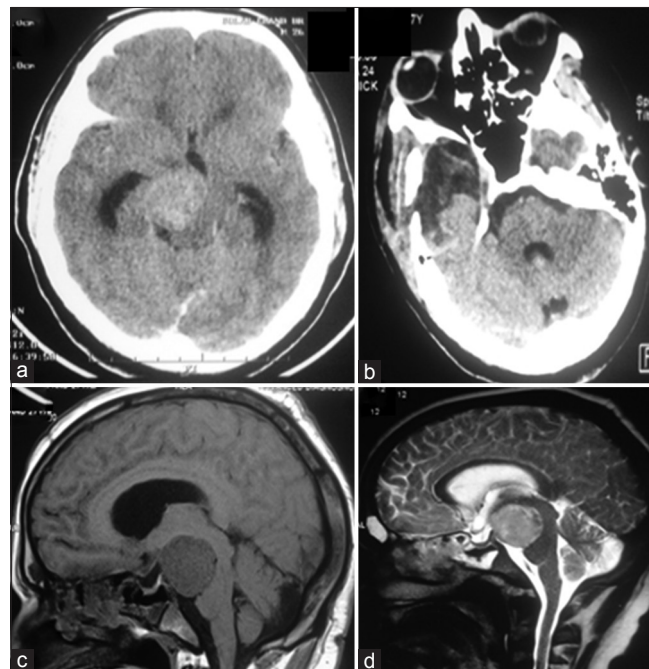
(a and b) Preoperative and postoperative computed tomography scan showing total excision of oculomotor nerve schwannoma. (c and d) Magnetic resonance imaging head sagittal cuts showing suprasellar mass lesion lifting up the third ventricle upward and to the opposite side with proximal ventriculomegaly and periventricular lucencies
